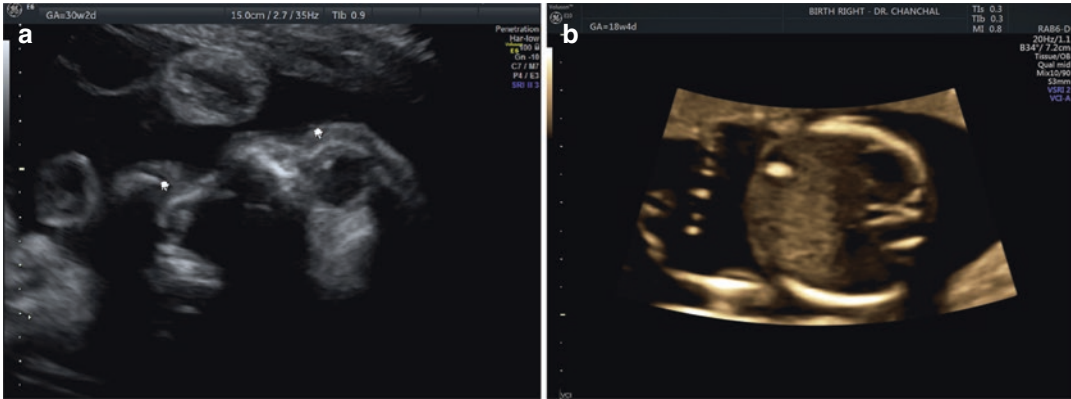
(a) 2D ultrasound showing bilateral cataract in a fetus diagnosed with Rubella infection. (b) Hepatic calcification in a fetus with CRS
